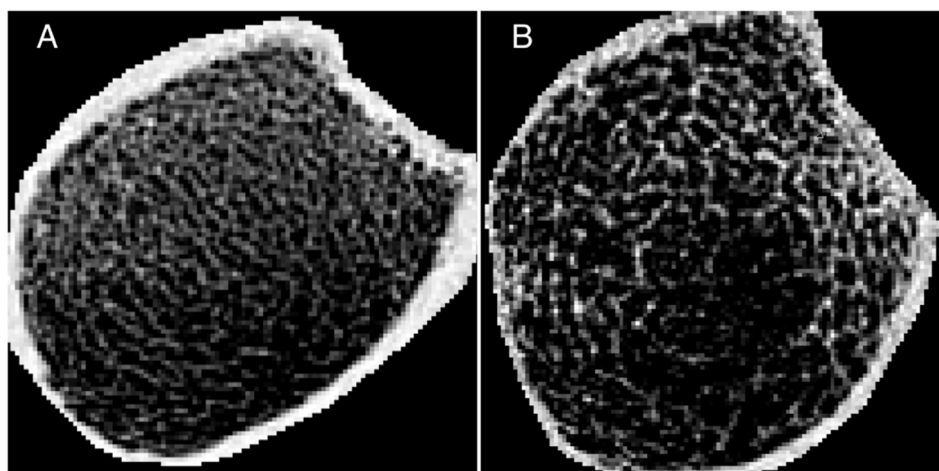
Intensity-inverted magnetic resonance images (MRI) of distal tibia of two study participants respectively showing (A) compact cortical bone and well connected trabecular bone compartment; and (B) thinned and porous cortical bone and disconnected trabecular bone regions.
